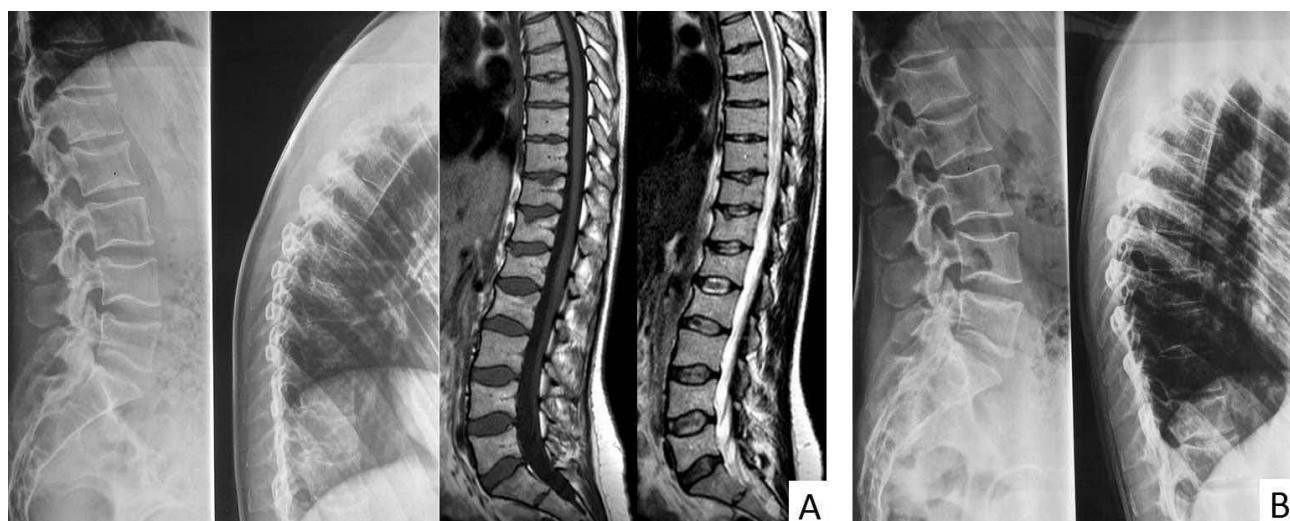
Radiological findings after 3 and 6 months of treatment. (A) X-ray and T1- and T2- weighted MRI after 3 months of treatment showing good consolidation of fractures. (B) X-ray after 6 months of treatment showing complete healing and no new fractures occurrence.
